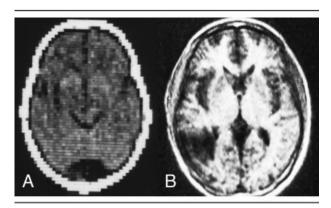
Noncontrast computed tomographic scan of the brain from 1974 (A) and magnetic resonance image of the brain from 5 years later (B) provided novel depictions of the human brain, albeit at limited resolution.
